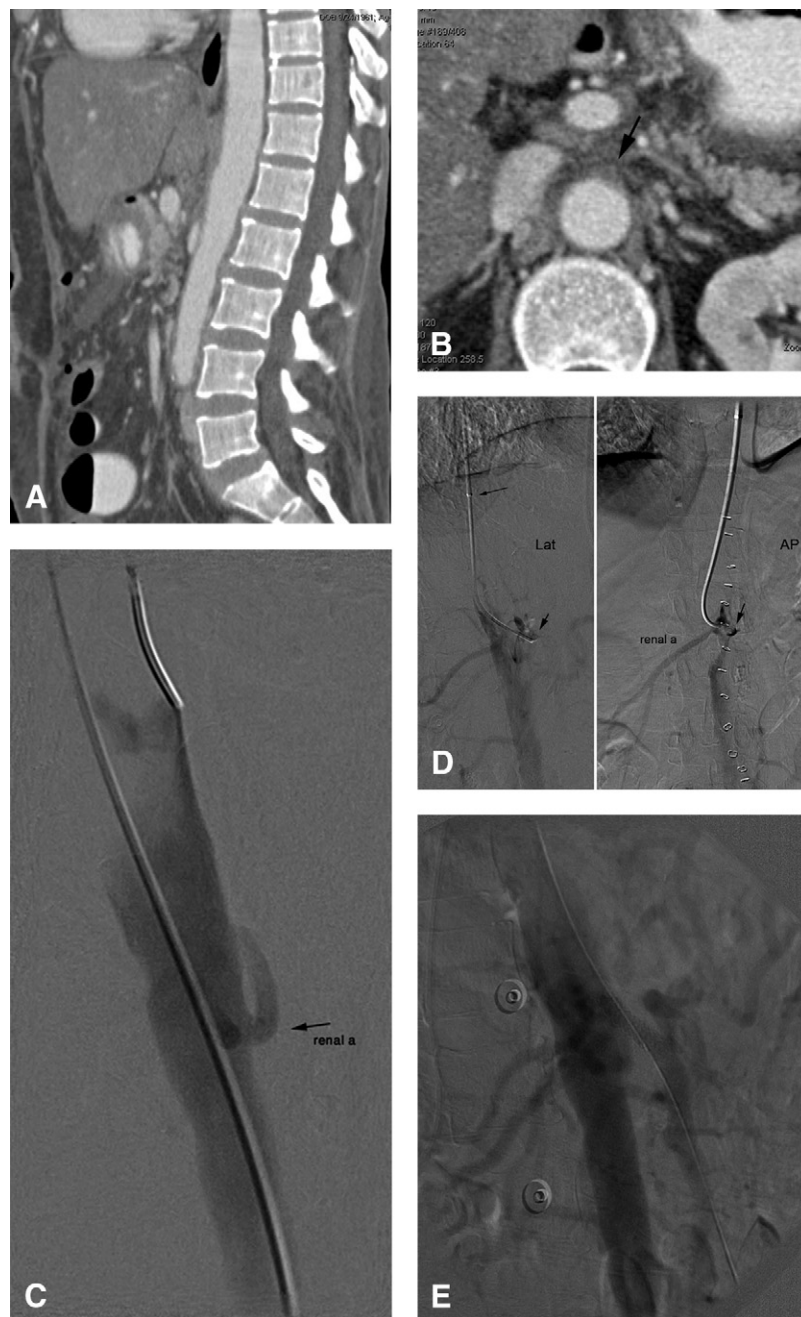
Example of recanalization of occluded superior mesenteric artery (SMA) in the setting of an obliterated stump in a 47-year-old woman who presented with an acute abdomen. During exploratory laparotomy, she was found to have an intra-abdominal abscess with extensive inflammation, segmental of patchy ischemia of the small bowel, and a pulseless mesentery. Revascularization was deemed difficult given the hostile abdomen. A, Lateral reconstruction of a contrast-enhanced computerized tomography (CT) of the abdomen shows occlusion of the celiac artery (CA) and SMA with no visible stumps. B, Axial slice demonstrates an obliterated stump of the SMA, which is just above the takeoff of the renal arteries. C, Lateral flush aortogram from a brachial approach demonstrates a featureless suprarenal aorta with no stumps visualized. D, Probing anteriorly at the level of the renal artery engaged the obliterated stump of the SMA, with subsequent subintimal recanalization. E, Final angiography following deployment of a 5- x 28-mm balloon-expanded stent.
